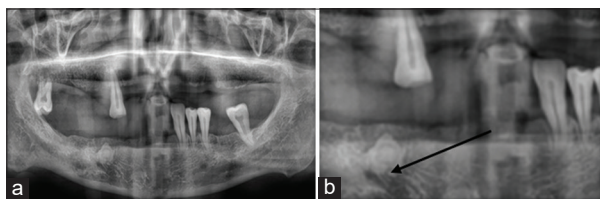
(a) Orthopantomogram (OPG); (b) OPG showing odontome (case 5)
